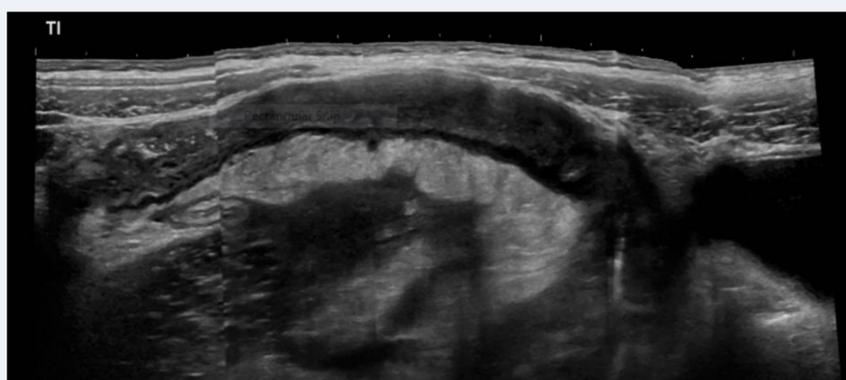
Panoramic ultrasound image of 10-15 cm of the distal ileum demonstrating marked mural thickening, mesenteric inflammation and associated lymphadenopathy in keeping with active inflammation.
